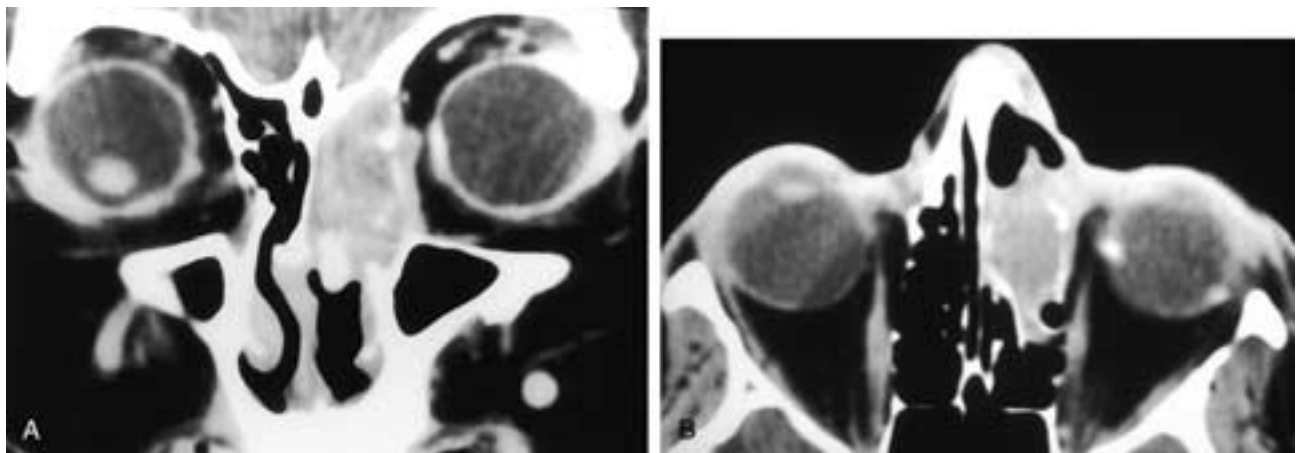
Coronal (A) and axial (B) CT scans show a slightly expansile mass in the left ethmoid sinuses. Although there is some destruction of the lamina papyracea with minimal invasion of the orbit, there is also an element of widening or remodeling of the ethmoid complex. This patient had a mucoepidermoid carcinoma.
